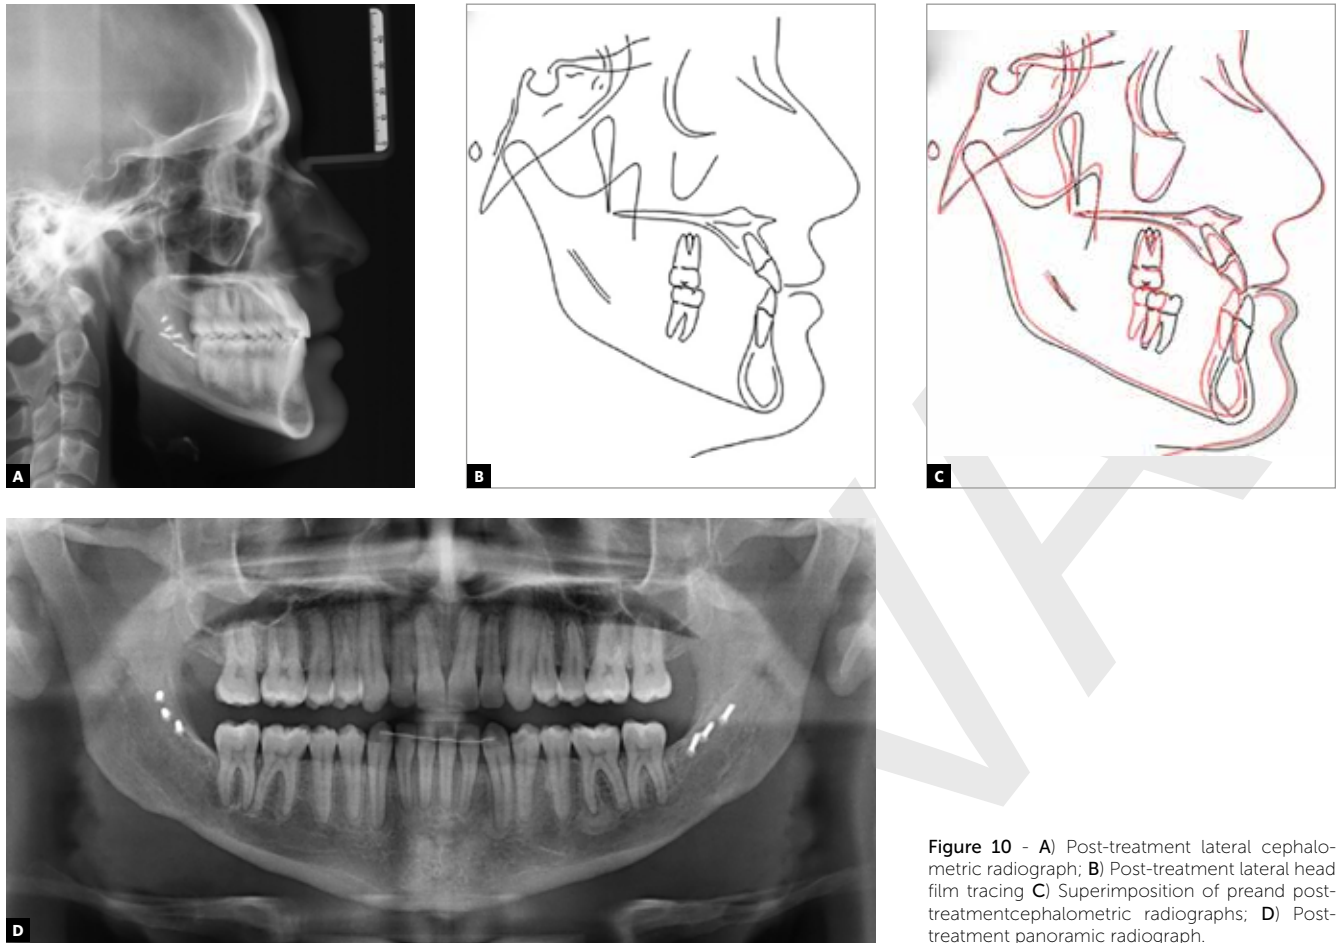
A) Post-treatment lateral cephalometric radiograph; B) Post-treatment lateral head film tracing C) Superimposition of preand post-treatmentcephalometric radiographs; D) Post-treatment panoramic radiograph.
